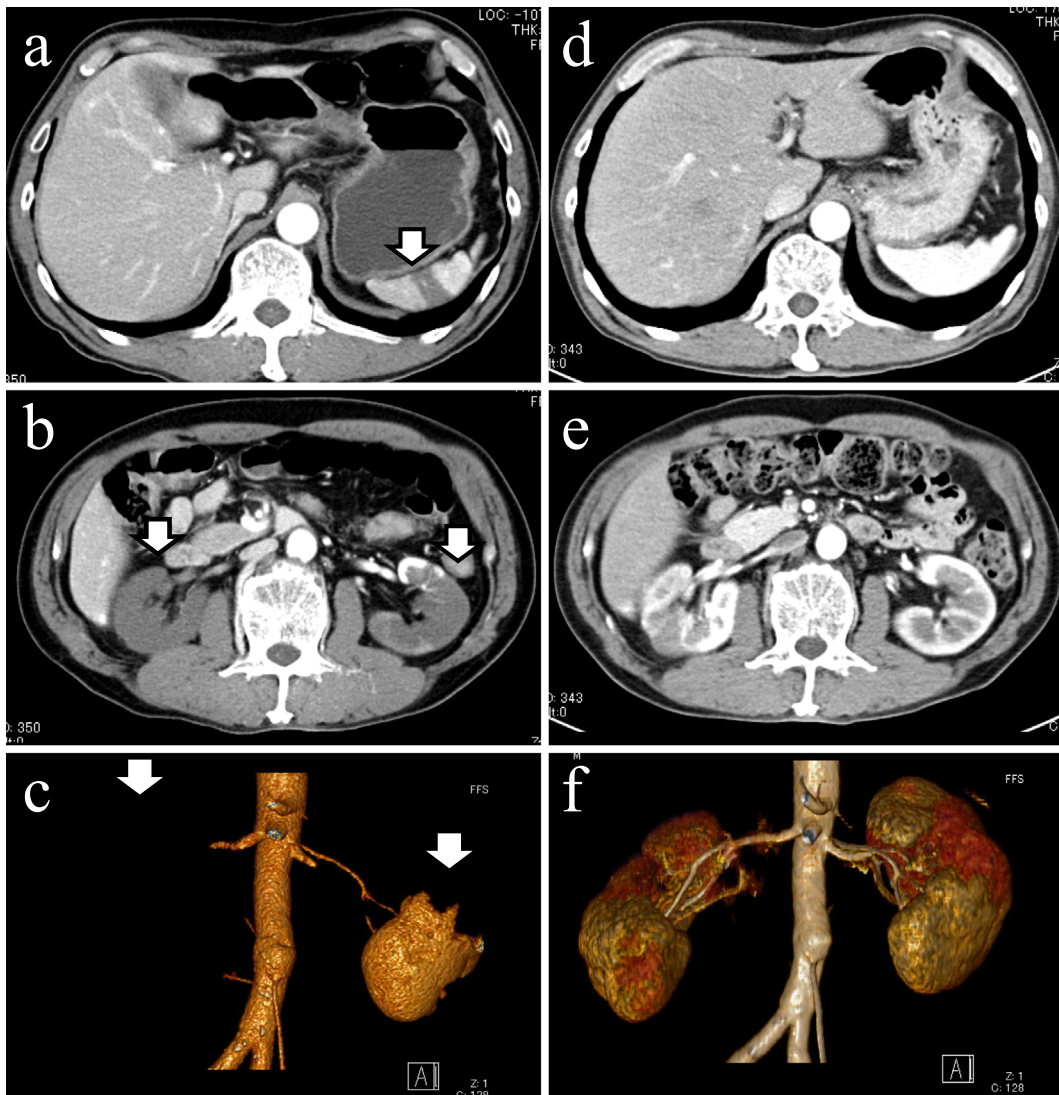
A contrast-enhanced CT scan revealing perfusion defects (arrows) in the spleen (a), kidney (b, c) on the ninth day. The perfusion defects decreased significantly on the 29th day after treatment with unfractionated heparin (d-f).
